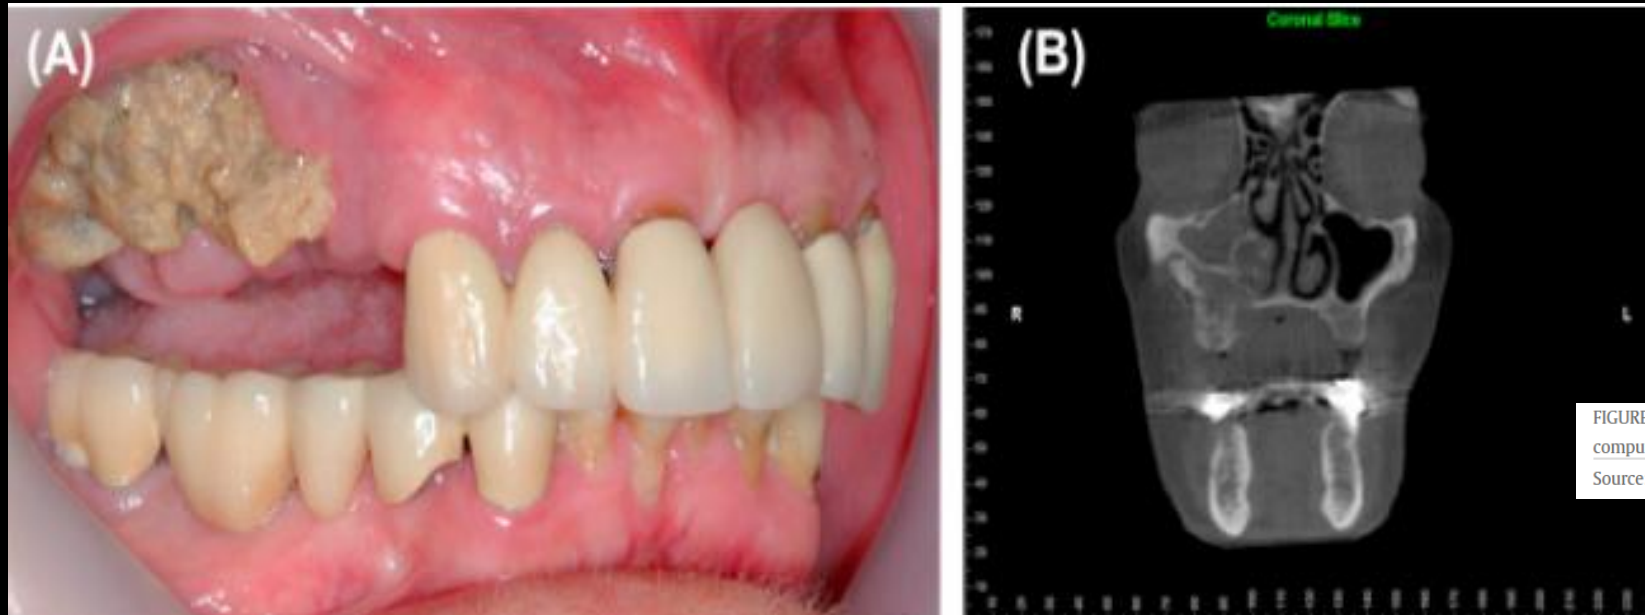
A, patient with Stage 3 bisphosphonate-associated osteonecrosis of the right maxilla. B, computed tomography scan of the same patient, coronal view.
